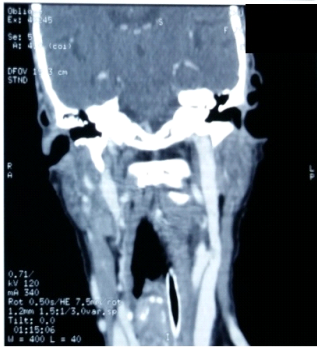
coronal CT image demonstrating stability tumor of the thyroid after 6 month of radiation
